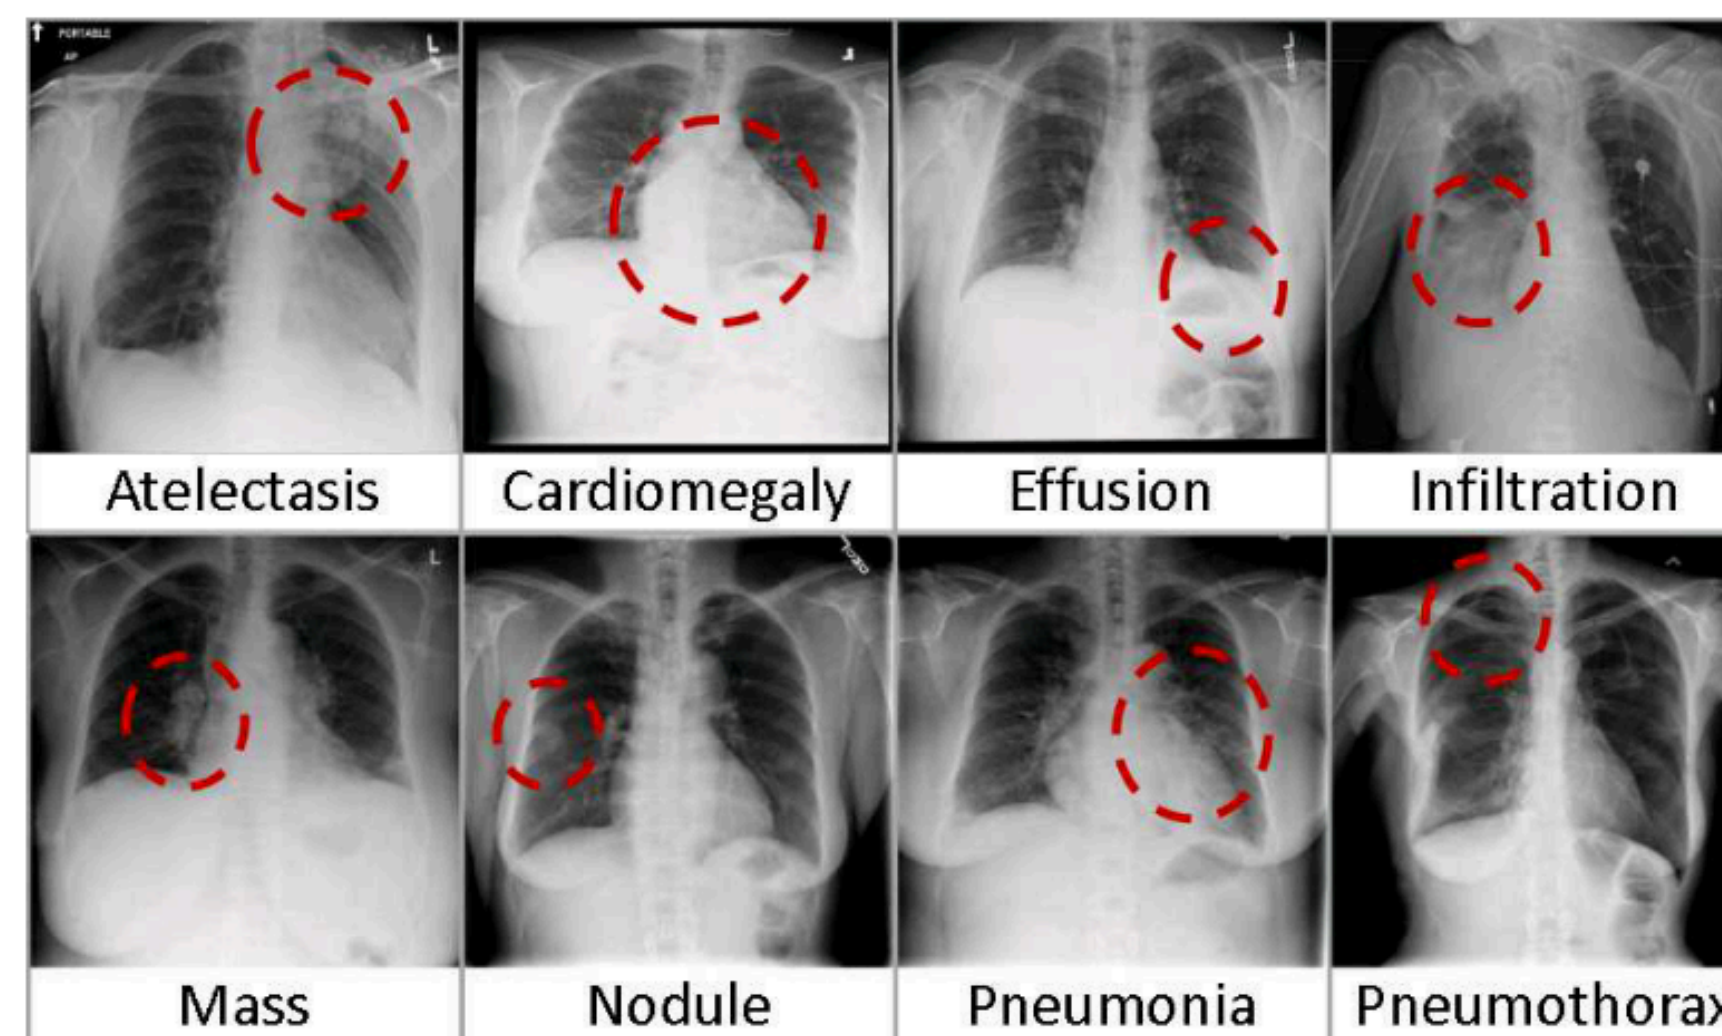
Eight common thoracic diseases observed in chest X-rays that validate a challenging task of fully-automated diagnosis.
